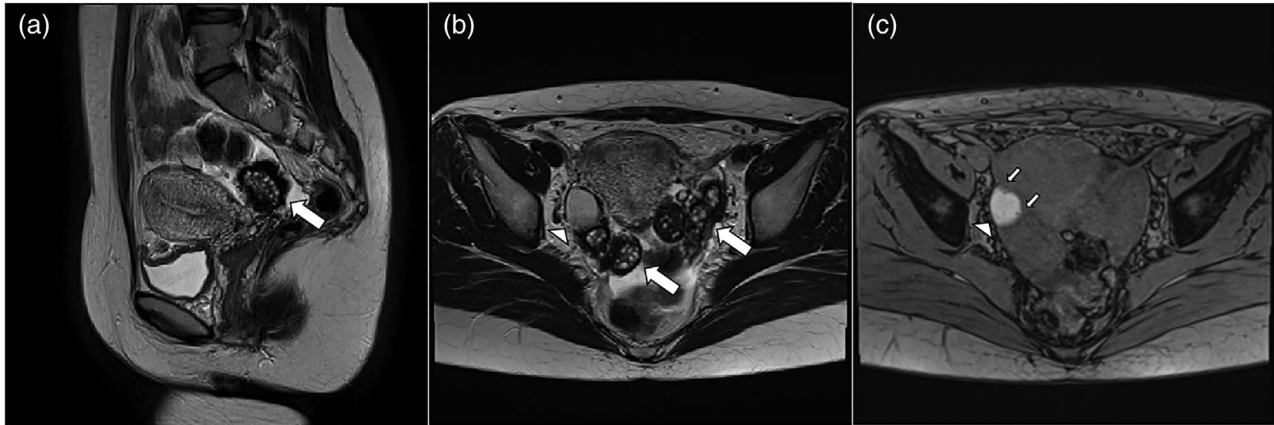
(a) Sagittal and (b) coronal views on T2-weighted magnetic resonance imaging (MRI), and (c) coronal view on T1-weighted MRI. The bilateral ovaries exhibited a lobulated nodular structure containing many minute cysts and the margin had a thick capsule with low signal intensity on T2-weighted imaging (large arrows). In addition, a 26×18 -mm cystic mass with a clear boundary exhibiting markedly high signal intensity on T1-weighted imaging, low signal intensity on T2-weighted imaging newly developed in the right ovary (arrow heads) and minute mural nodules were found in the mass (small arrows)
